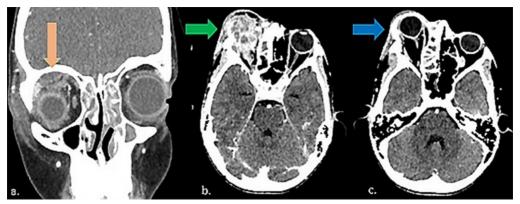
(a) A coronal view of the CT scan revealed a hypodense, enhancing subperiosteal collection on the roof of the right orbit, compressing the eyeball downward (orange arrow) with pansinusitis; (b) and (c) Axial view showed right superior subperiosteal abscess (green arrow) and severe proptosis with orbital cellulitis (blue arrow) (different levels of axial cut).
